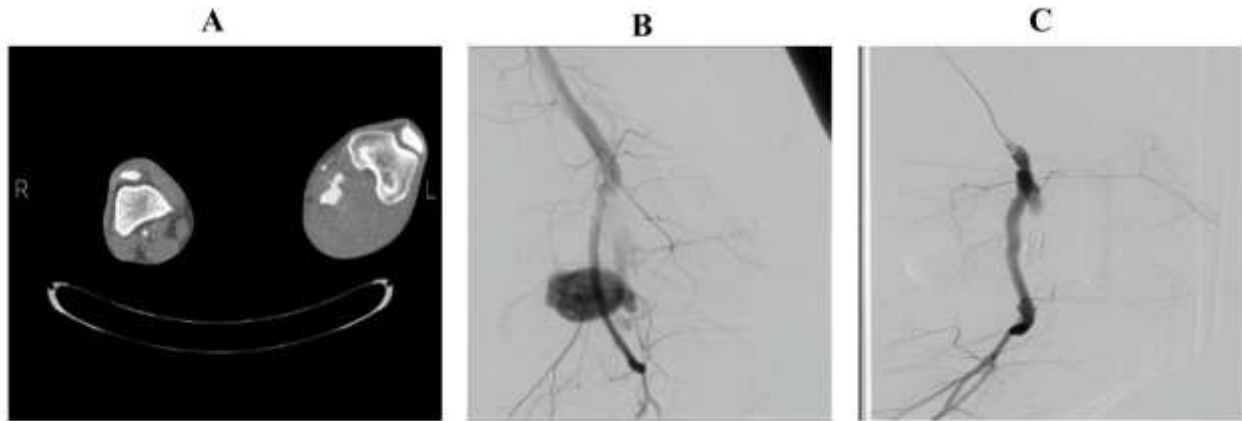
A 31-year-old patient with popliteal PA following gunshot to popliteal after open surgical femoropopliteal bypass with a saphenous vein. (A) Contrast-enhanced computed tomography (CT) demonstrates popliteal PA. (B) Angiography shows popliteal PA with active extravasation of contrast. (C) PA is filled by coil from the proximal and distal of the pseudoaneurysm, and normal blood flow in the bypass graft is observed. Because of a massive hematoma that cannot drain with radiologic intervention, open drainage was considered.
